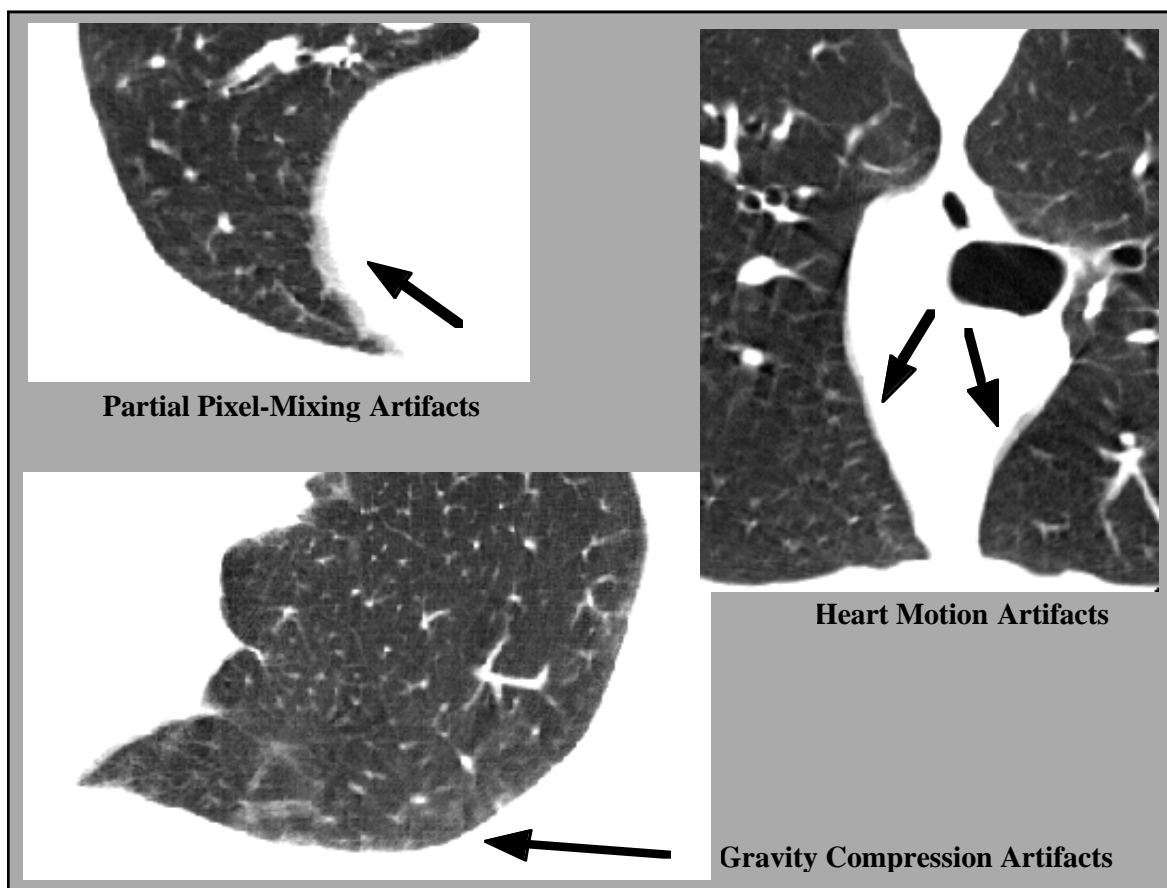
Examples of Artifacts in HRCT Lung Imagery
